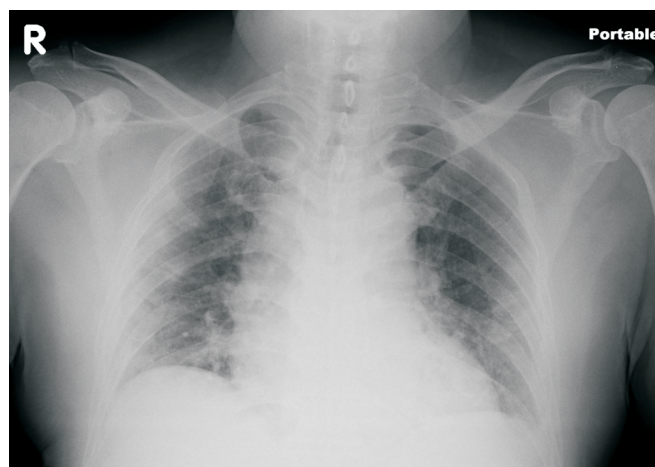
CXR on hospital day 1 showed hazy infiltration in both lower lung fields, suspect hypoventilation related. CXR: chest X-ray.
